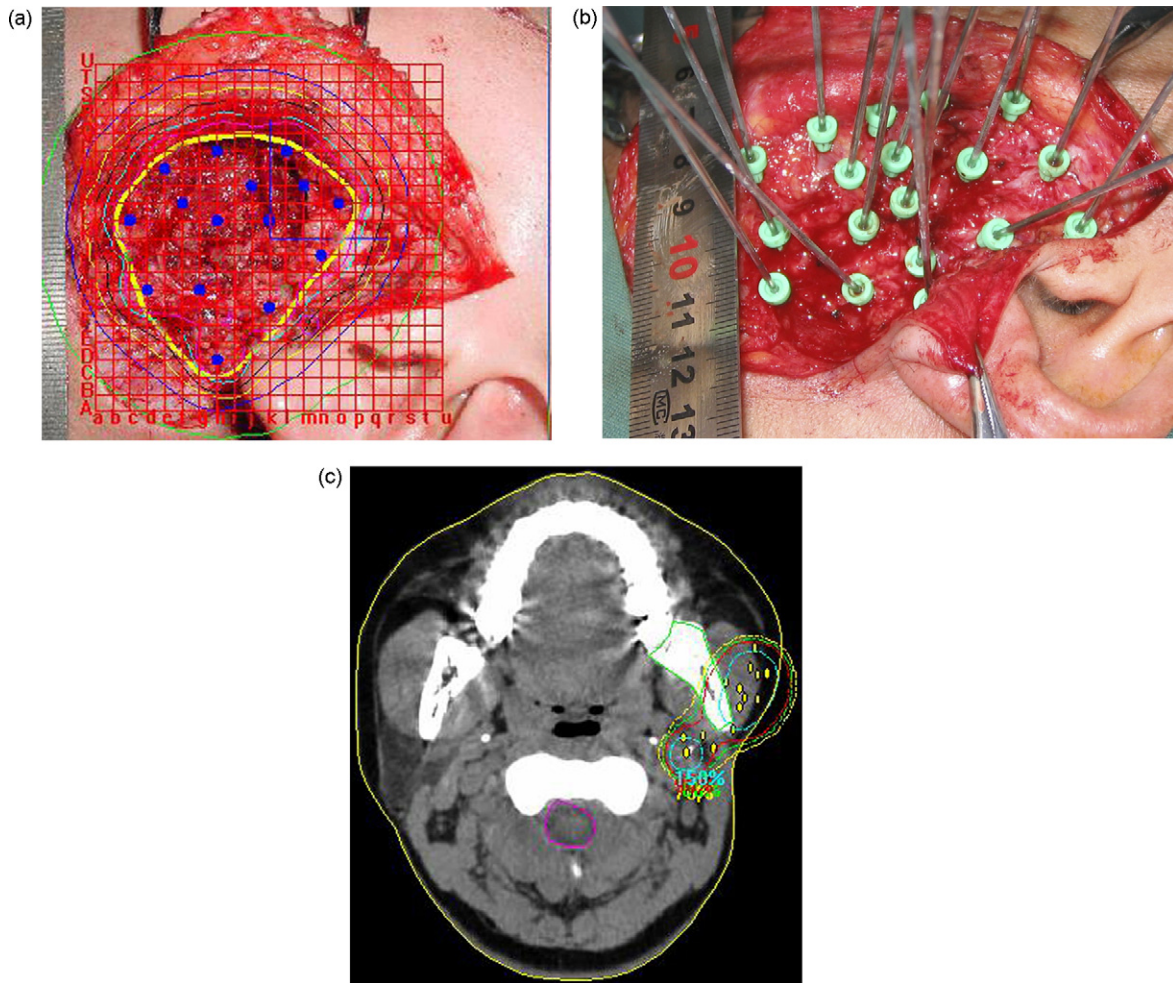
(a) Implant plan for TPS seeds; blue dots indicate seed position, the yellow line is the target area. (b) Seeds implanted. (c) CT verification of the dose and seed position; the yellow dot shows the seed and the red line is the 90% dose isodose line.
